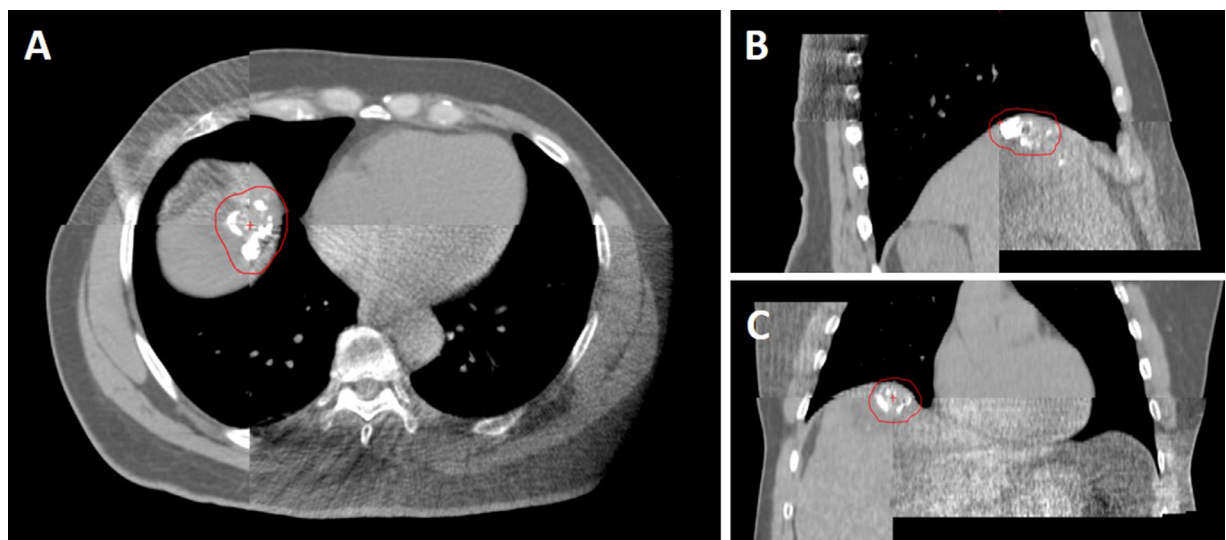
SBRT alignment CBCT showing setup of a liver dome lesion with excellent visualization of LC Bead LUMI. *Abbreviations:* CBCT = cone beam computed tomography; SBRT = stereotactic body radiation therapy.
